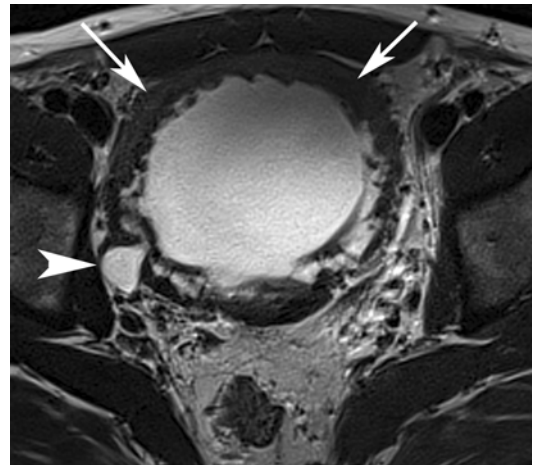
Axial T2-W MR image of a 29-year-old man with neurogenic bladder and resultant bladder wall thickening (*white arrows*) and diverticulum (*white arrowhead*). This patient had chronic prostatitis (see Fig. 17.19a, b)
